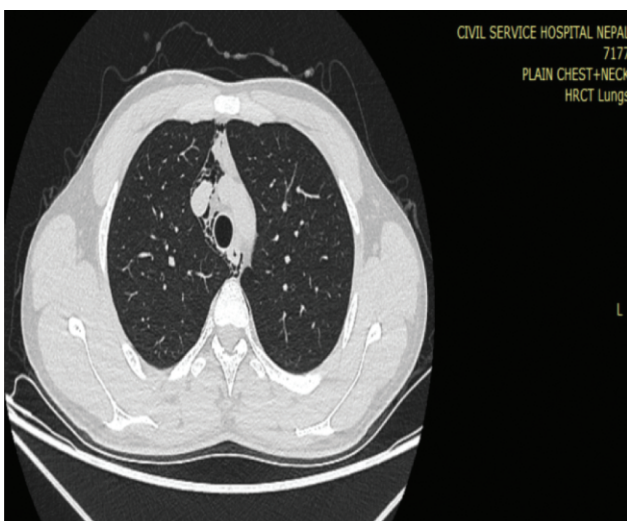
CT scan chest lung window showing Pneumomediastinum
